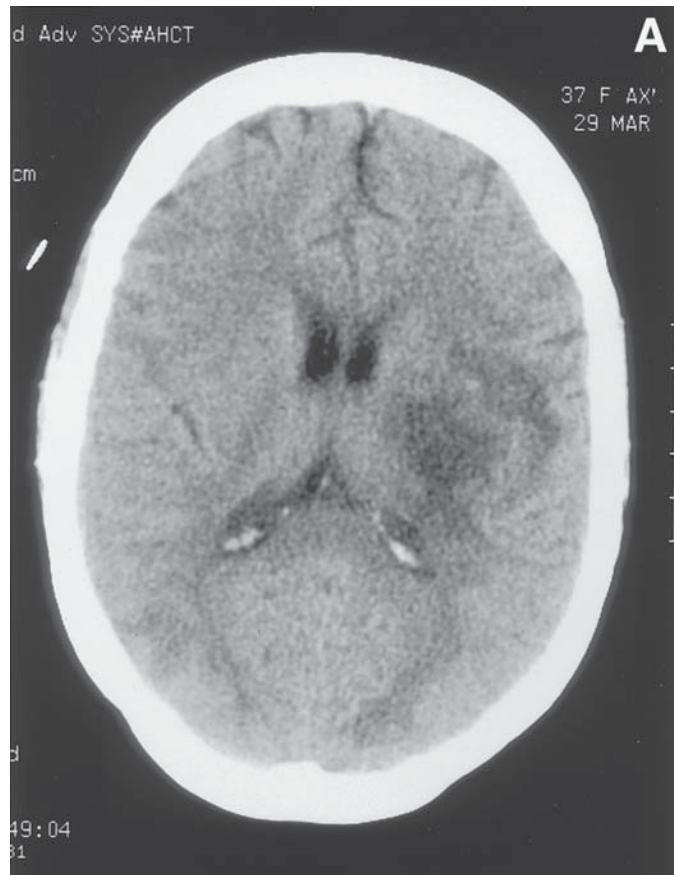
CT and MRI in a 37-yr old woman with aspergillosis. She presented with low-grade fever, which was followed by abrupt onset of dysarthria and mild right hemiparesis. Initial unenhanced CT shows multiple areas of low attenuation including a lesion in the left basal ganglia and centrum semi-ovale (A). (B) Axial fluid-attenuated inversion recovery (FLAIR) imaging shows area of high signal in left hemisphere. (C) Basal ganglia lesion is hyperintense on diffusion-weighted sequences. The patient's level of consciousness and the right hemiparesis deteriorated over the next week. Further CT showed hemorrhagic transformation of the left cerebral hemisphere lesion with extension of hemorrhage into the lateral ventricle (not shown).
